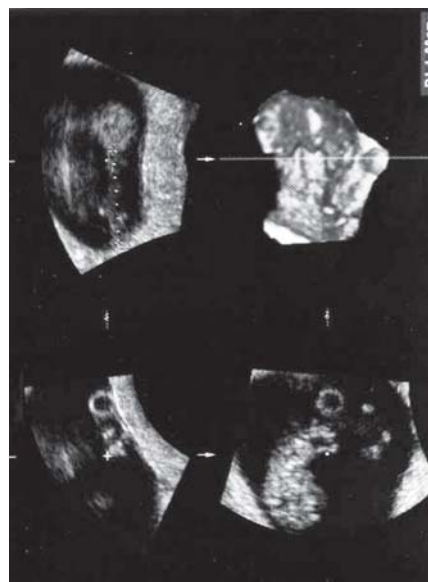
First trimester fetus assessed by 3D ultrasound. Note position of the fetus and umbilical cord in X, Y, Z planes to obtain full umbilical cord length for measurement
